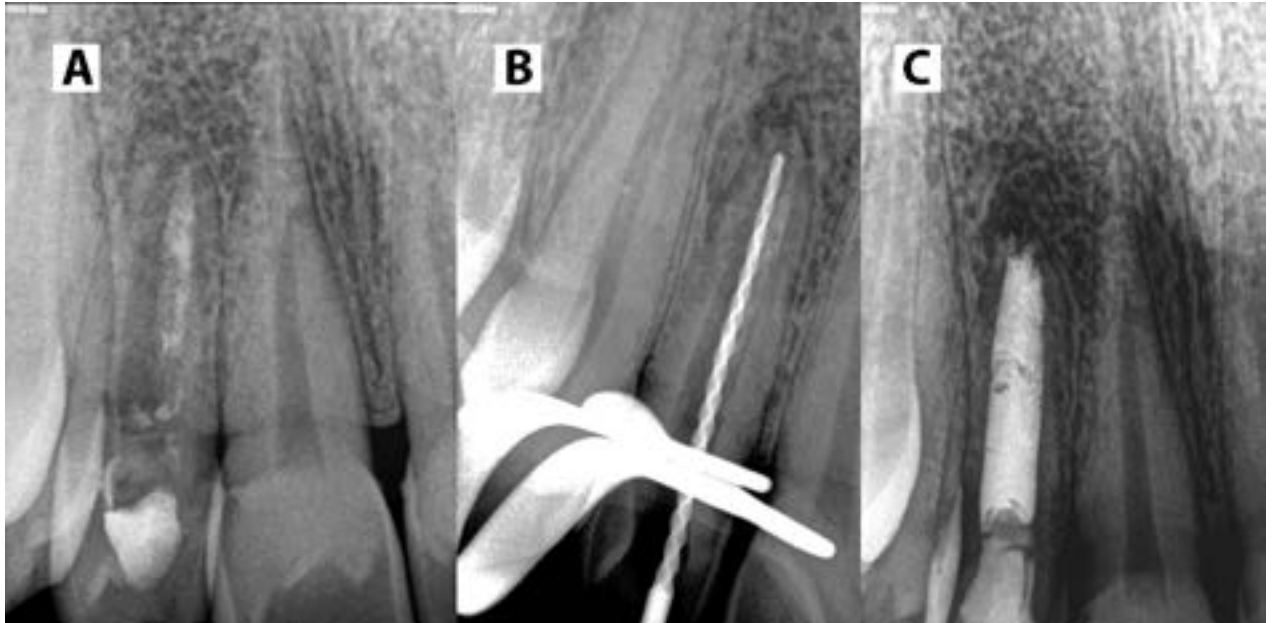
A) A two-year, follow-up periapical radiograph, revealing resolution of the periapical pathology B) working length confirmation with a large diameter k-file C) immediate post-operative periapical radiograph.
